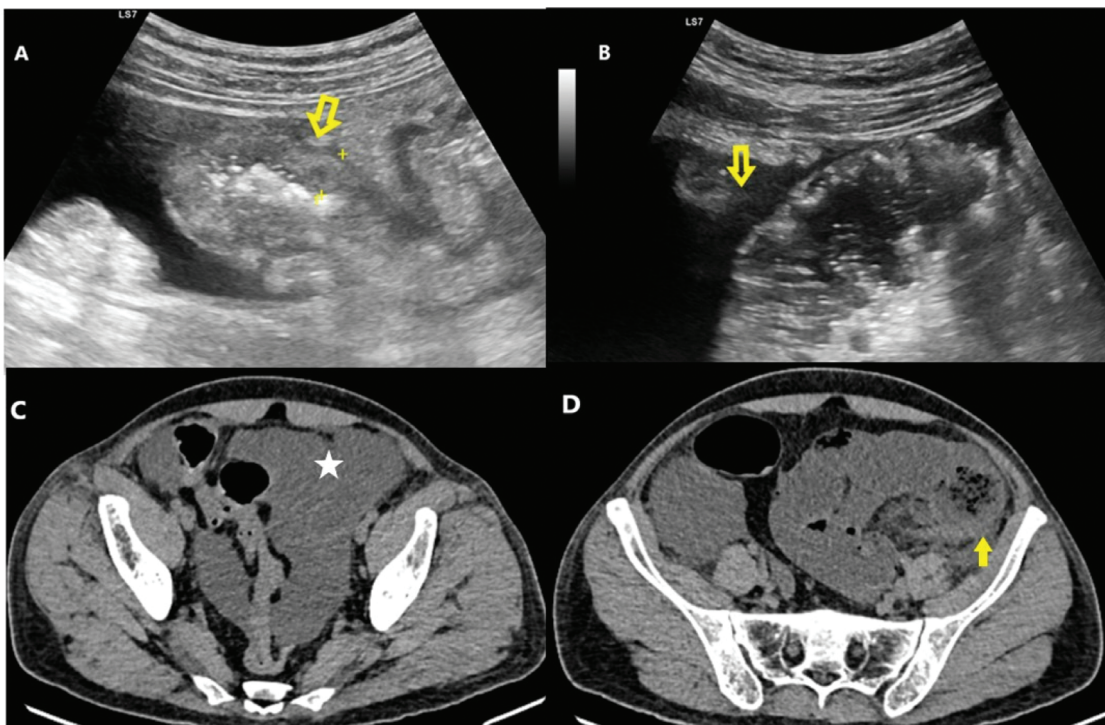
(A) Ultrasound image showing thickened edematous bowel wall (yellow arrow). (B) Ultrasound image showing peritoneal free fluid (yellow arrow). (C) Computed tomography (CT) image showing pelvic free fluid (asterisk). (D) CT image showing edematous bowel wall thickening (yellow arrow).
